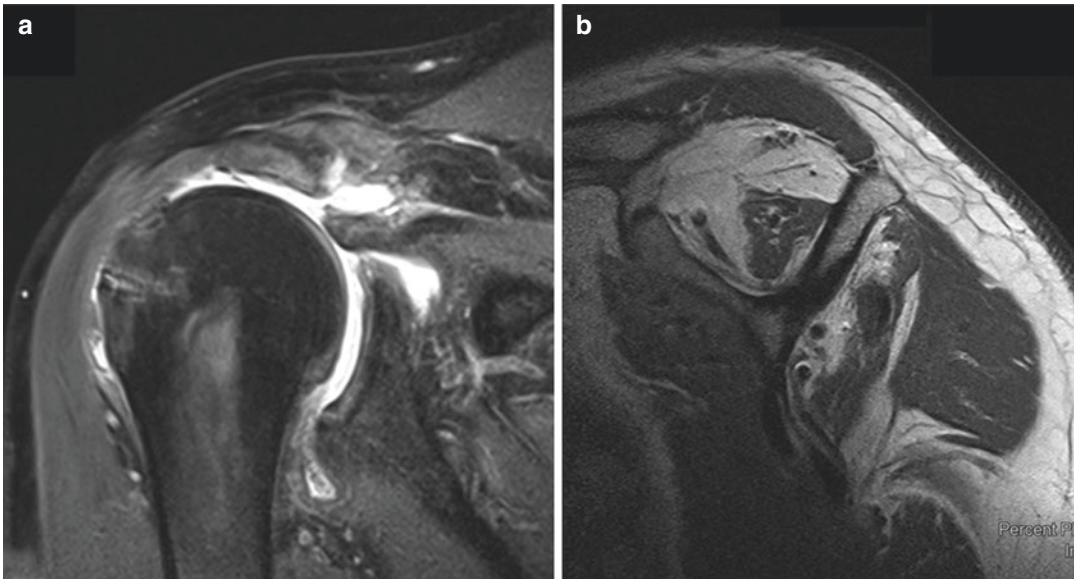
MRI scan demonstrating a massive re-tear of the rotator cuff tendons with retraction, atrophy, and fatty infiltration. (a) Coronal view and (b) sagittal view
